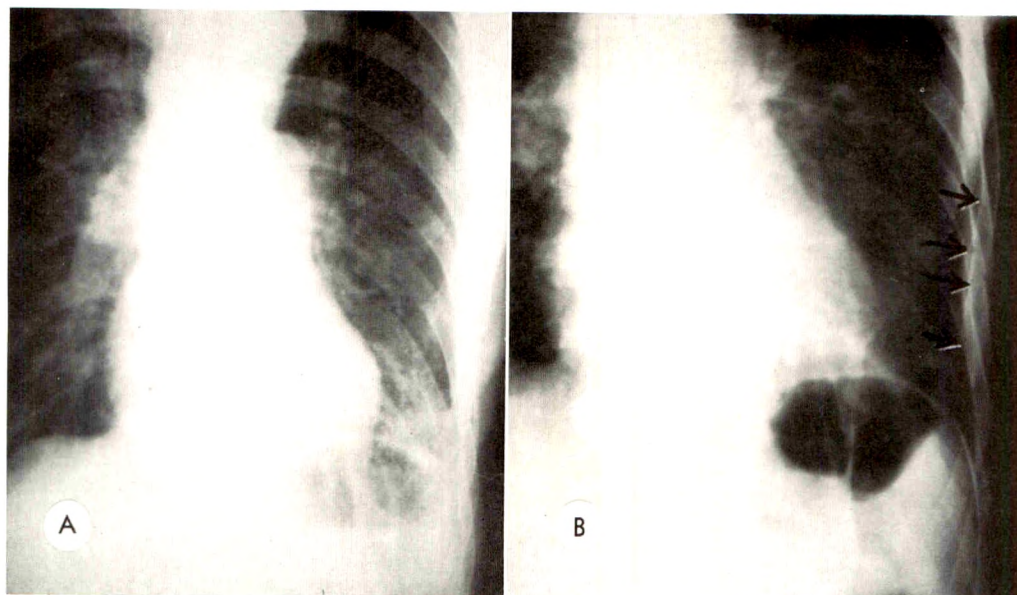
Clinical myopia. (A) Abnormal changes at base of left lung read as "pneumonia," without knowledge of history of trauma. (B) A day later, the rib fractures were clearly evident and were also discernible on the original roentgenogram. The pulmonary lesion most likely represented a hematoma.
